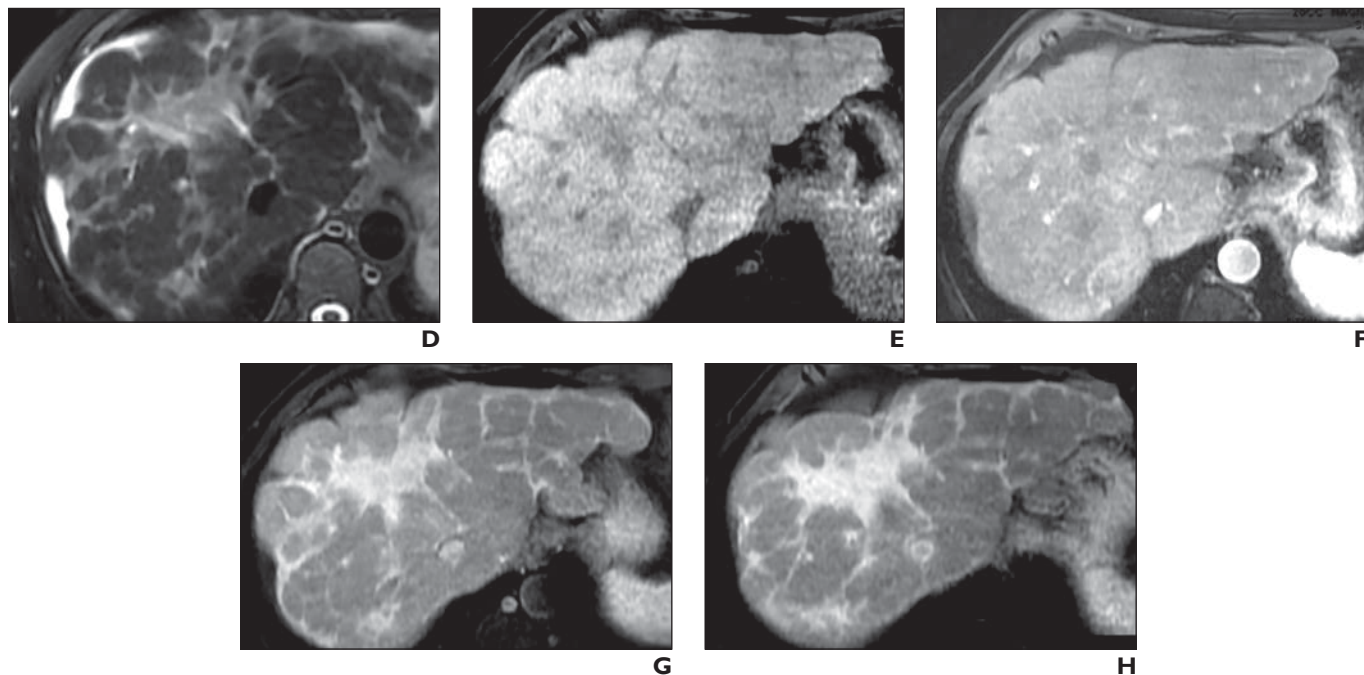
(continued)—55-year-old man with cirrhosis. Example of confluent fibrosis. MR images show sheetlike areas of increased signal intensity on T2-weighted image, decreased signal intensity on T1-weighted image, and delayed phase enhancement. This is typical of confluent fibrosis. Occasionally, areas of hyperenhancement may be present on arterial phase images. Areas of capsular retraction and volume loss may accompany fibrosis.
